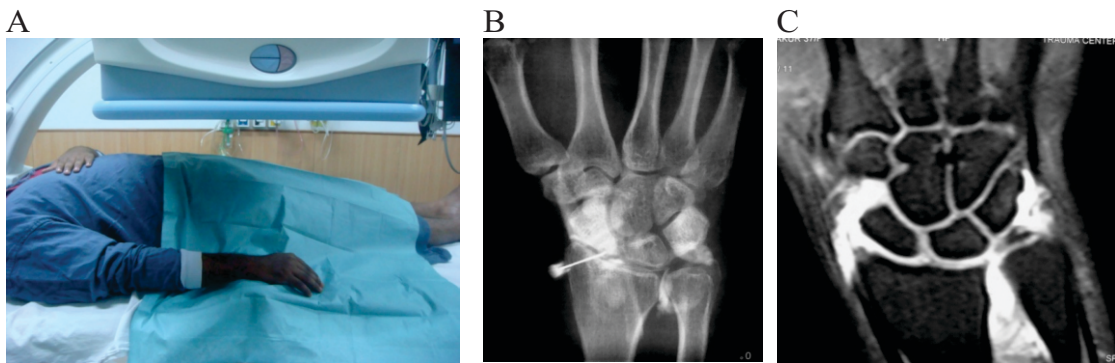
A to C: Arthrography in conjunction with a post arthrogram MRI of wrist in evaluation of triangular fibrocartilage complex (TFCC) Tears. A needle is placed into the joint under fluoroscopy (A). After proper position of needle, the joint is distended with contrast (B) and MR arthrogram is done. Coronal fat suppressed T1W MR arthrogram (C) is showing TFCC tear.
